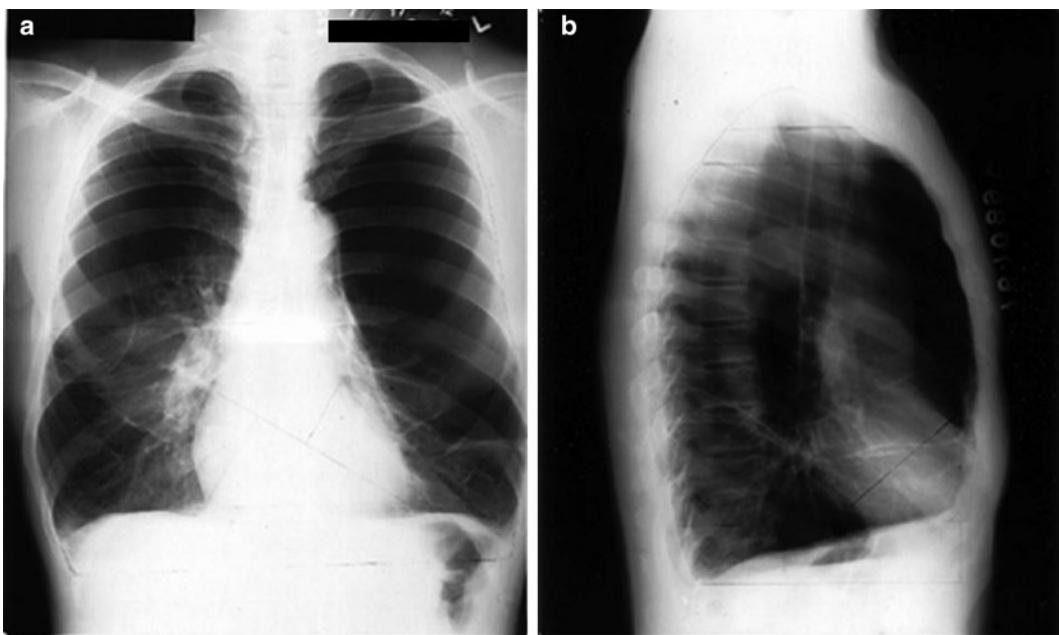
(a) A patient with emphysema. There is a marked hyperinflation with an increase in the anterior–posterior diameter of the chest. Also, there is flattening of the diaphragm bilaterally and a generalized increase in the blackness of the film. (b) The same patient a lateral chest X-ray.
